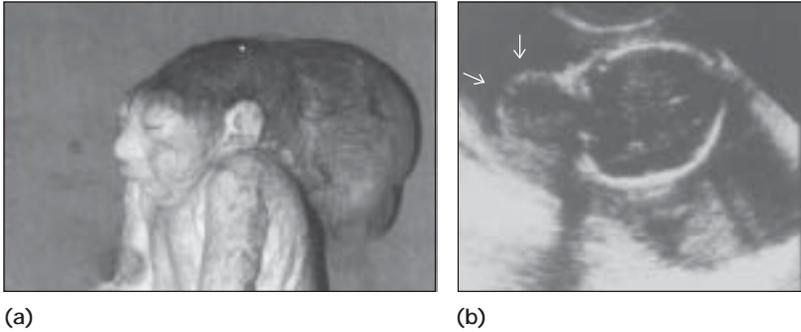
a A foetus with a large encephalocele. b Ultrasonogram showing a large encephalocele.
